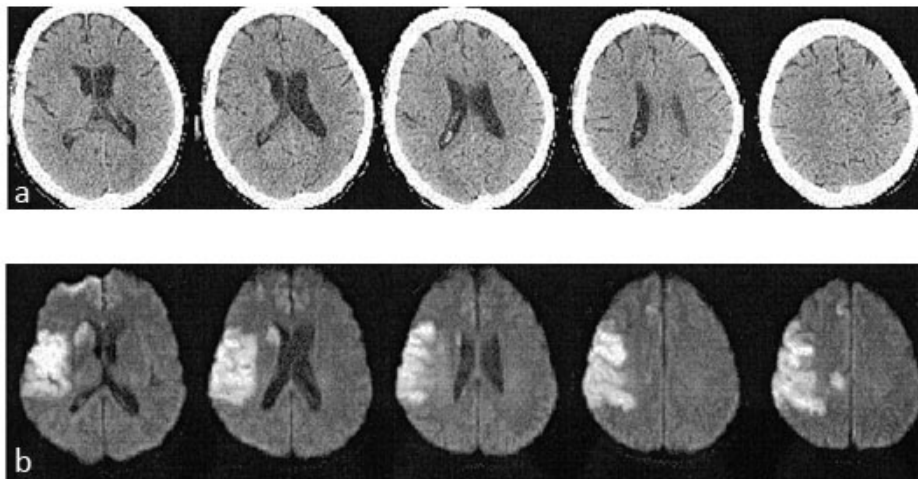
Comparison of CT and MRI Images (a).CT Image (b).MRI DWI Image
